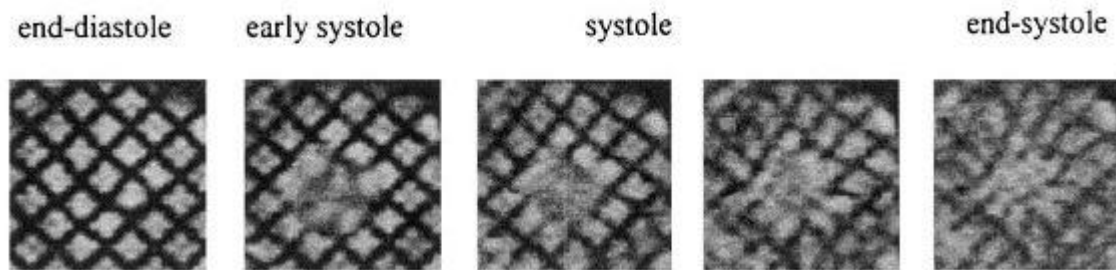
MRI SPAMM short axis images of left ventricle captured during a cardiac cycle. Adapted from [38].
